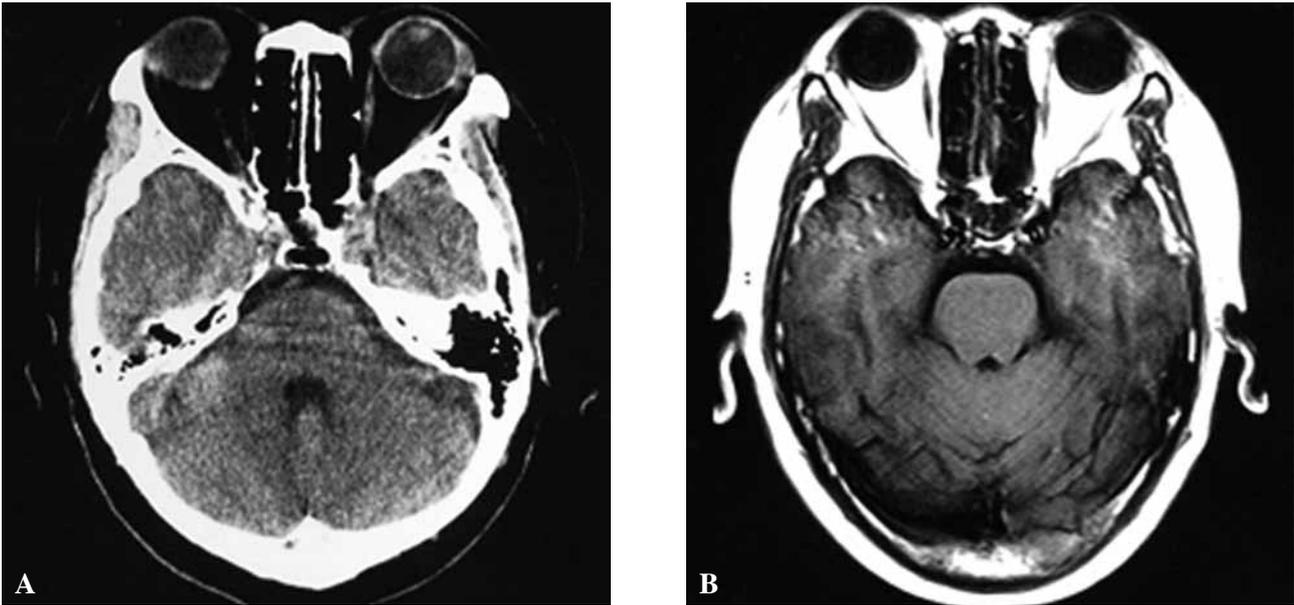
Axial CT (A) and MRI (B) scans showed no abnormalities around the cavernous sinus area
